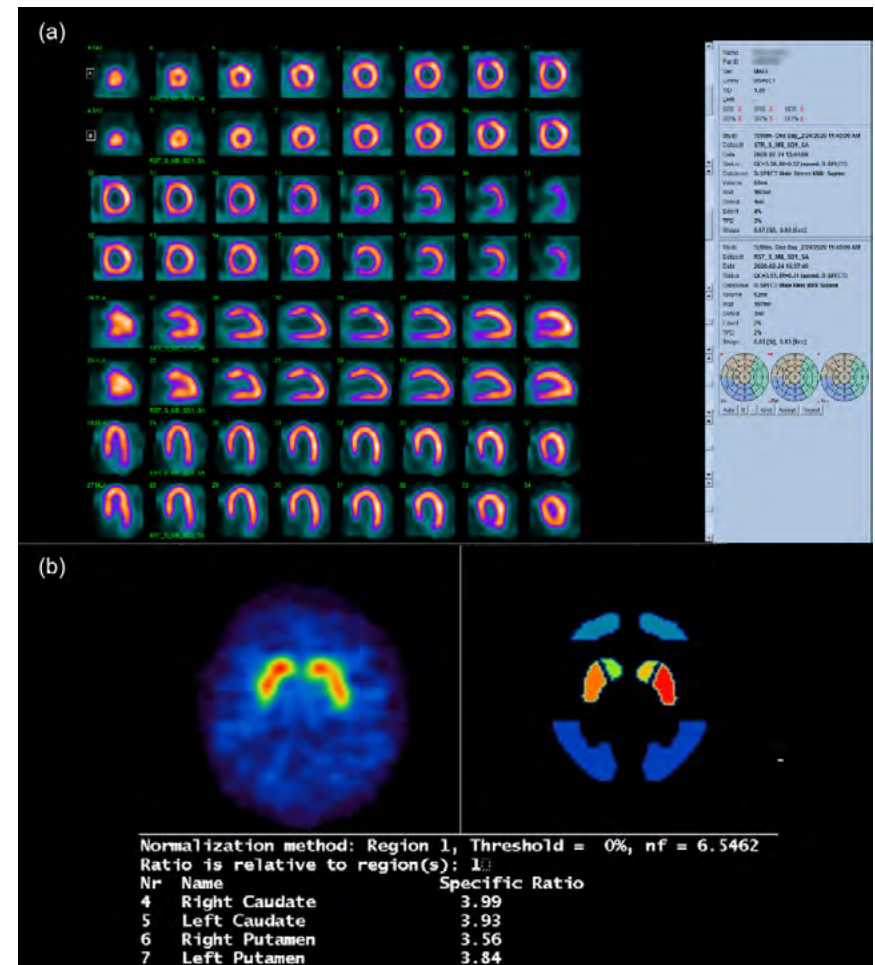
Examples of relative SPECT quantification in (a) myocardial perfusion imaging and (b) I-123 ioflupane SPECT.
